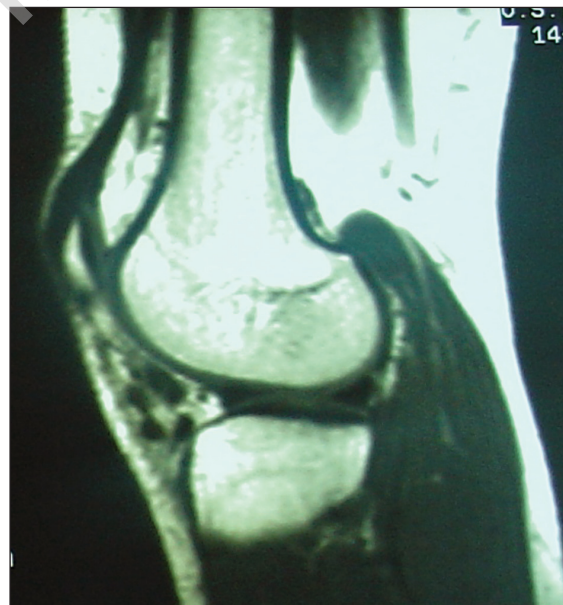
The previous MRI had shown a polycyclic, multilobular, septated mass, 3 cm in diameter. Note the cyst was located more distal than in Fig.1 and it did not reach the inferior pole of the patella.
